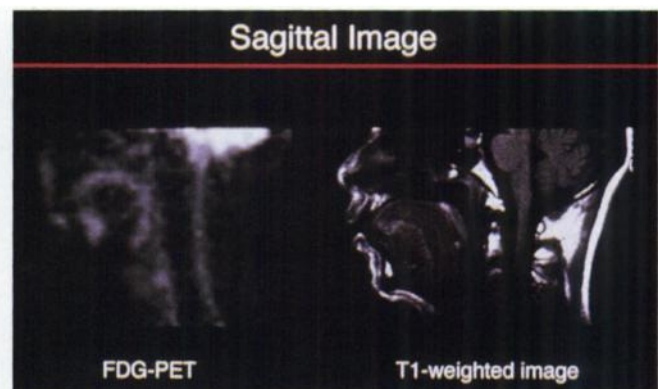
Use of FDG in locating recurrent head and neck cancer. No abnormalities were seen in this patient.
